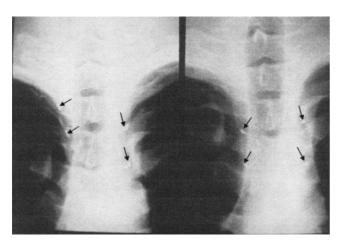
Chest roentgenographs during sympathetic blockade using the clipping method. Chest roentgenographs taken from a 20-year-old man undergoing T_3 sympathetic block for HCF. Arrows indicate the location of clips. The initial sympathetic block (left film) was clipped at the wrong (T_2) ganglion. Post-operatively the patient experienced right face anhydrosis. The clip was corrected (right film) and all side effects were resolved
